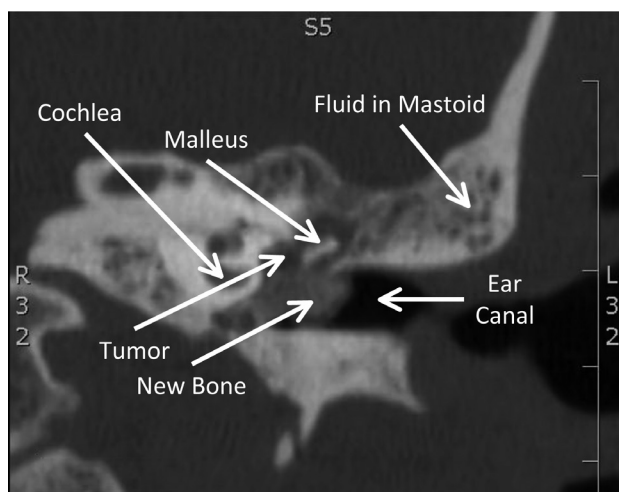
This axial CT of our patient's temporal bones at the level of the mid-tympanic membrane demonstrates opacification of the middle ear with surrounding bone formation bulging through the tympanic membrane.
